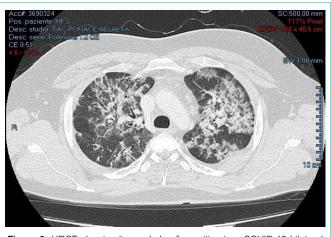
HRCT showing "ground-glass" opacities in a COVID-19 bilateral interstitial pneumonia.
